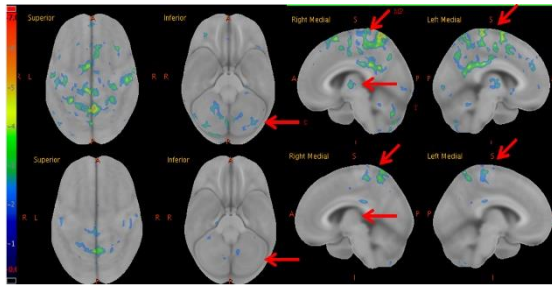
Z score images of a patient with ASD before and following cell therapy. Images were presented in axial and coronal. (Top) row: A significant decrease in distribution of ^{18}F -FDG is indicated by arrow before cell therapy; (Bottom) row: six months after the intervention of cell therapy shows improvement in the region of hypometabolism. Regions of interest (ROI) included are Medial parietal cortex (MP), Thalamus (T), and Cerebellum (C).
